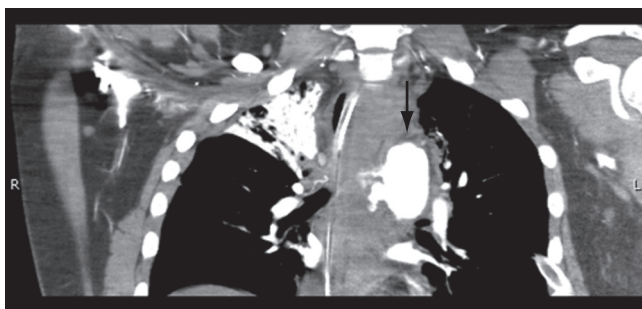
Chest computed tomography (CT) scan showing aortic injury with active extravasation (arrow).
